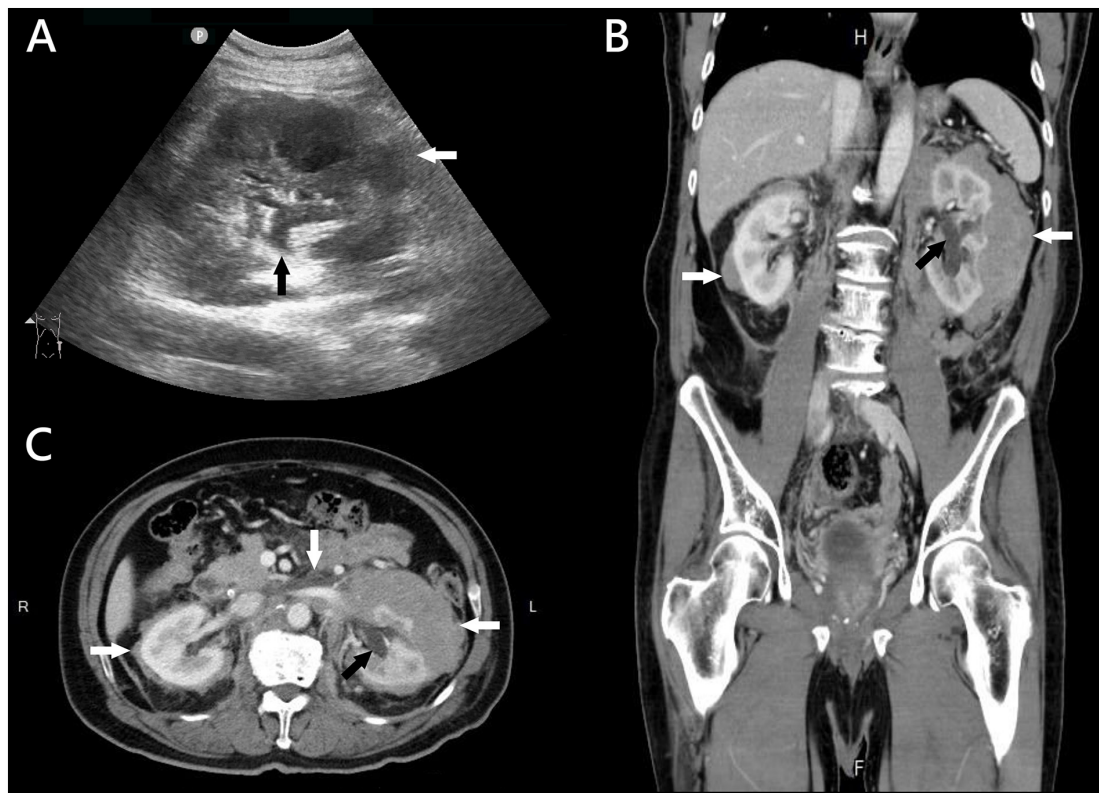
(A) Bedside point-of-care ultrasound of the left kidney revealed lobulated ill-defined hypoechoic foci in the perirenal spaces (white arrow) and mild hydronephrosis (dark arrow). (B) Coronal view of contrast-enhanced CT of the abdomen and pelvis showing low-density lesions in bilateral perirenal space and paraaortic space (white arrows), and mild hydronephrosis (dark arrow). CT, computed tomography. (C) Contrast-enhanced CT of the abdomen and pelvis with intravenous contrast (axial view) showing low-density lesions in bilateral perirenal space and paraaortic space (white arrows) and mild hydronephrosis (dark arrow).
